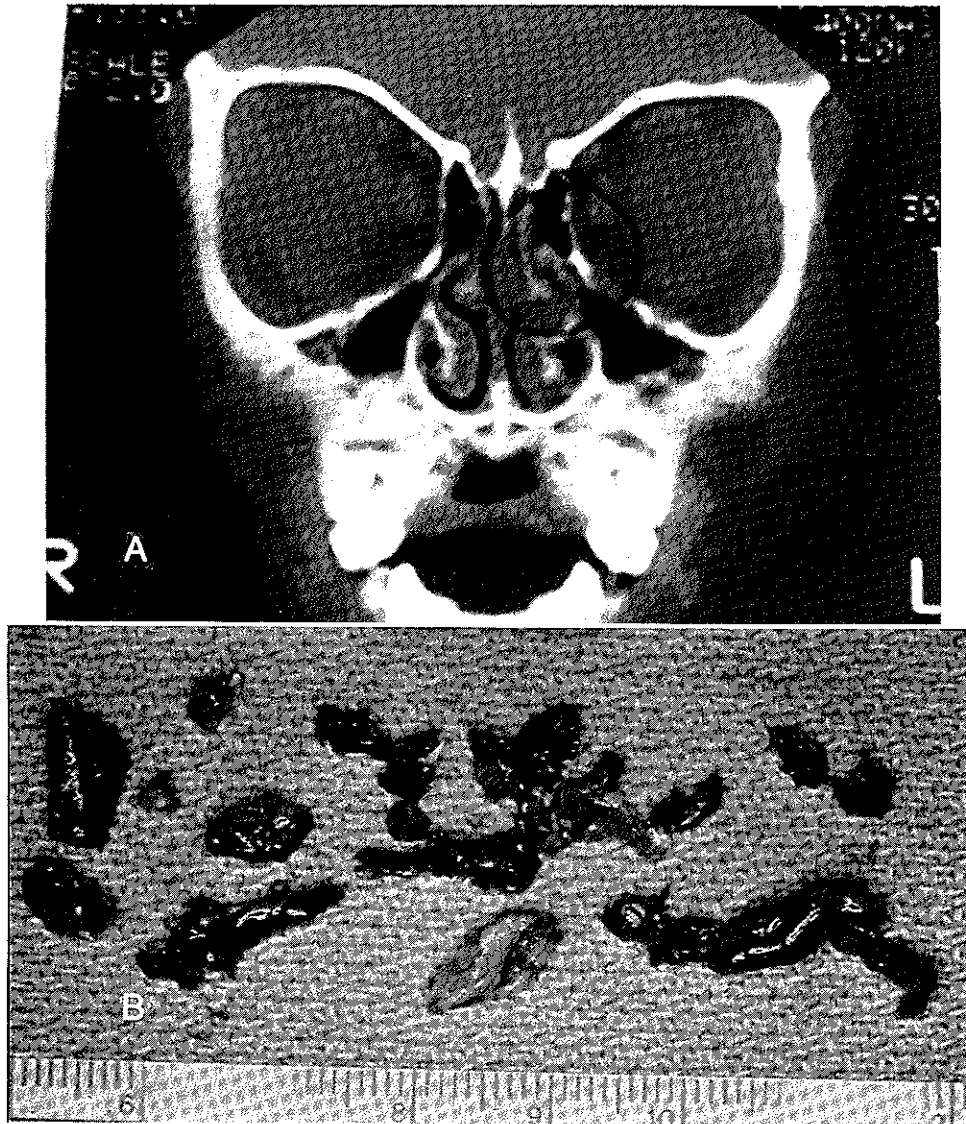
A, CT scan of the sinuses shows minimal ostiomeatal complex disease on the left side. B, Polypoid tissues removed during surgery from the same side during surgery.
